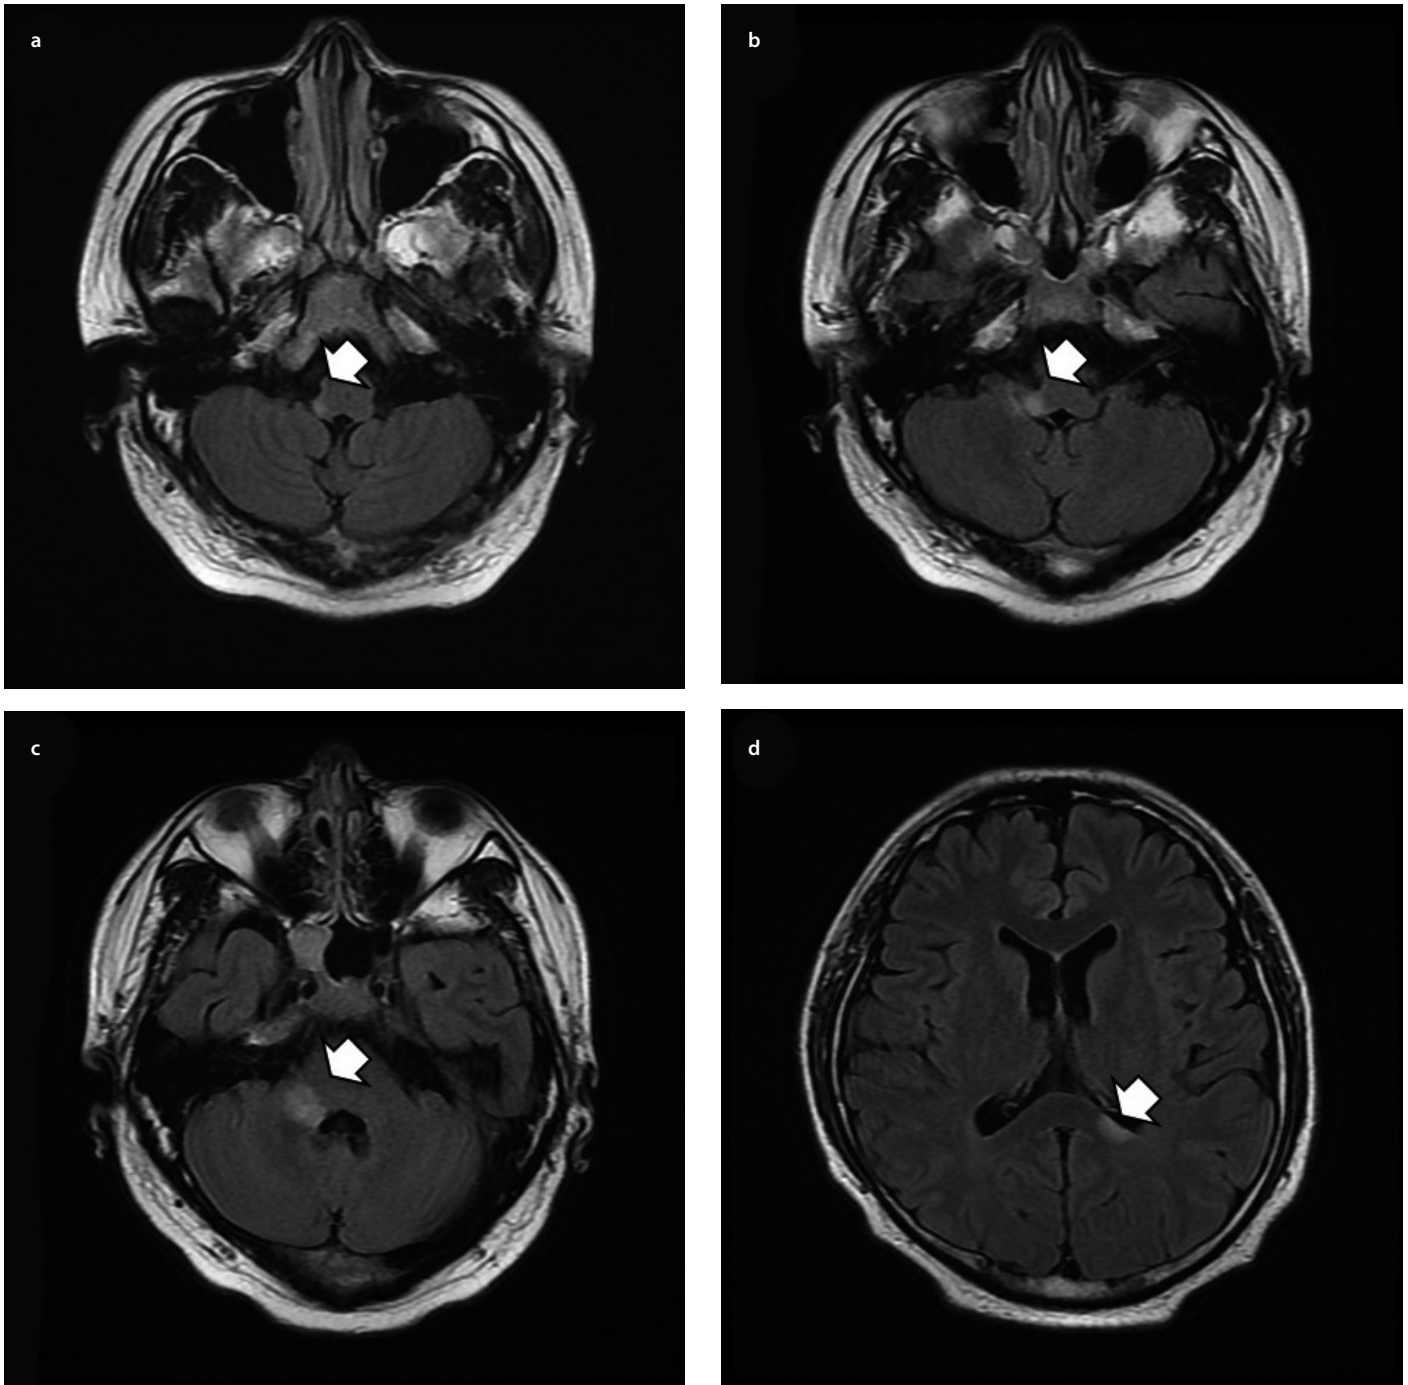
a-d. T2/FLAIR MRI images. Several T2/FLAIR hyperintense signal lesions (white arrow) in the right lateral midbrain (a, b), the right cerebellar peduncle (c), and the left temporal periventricular white matter (d).
